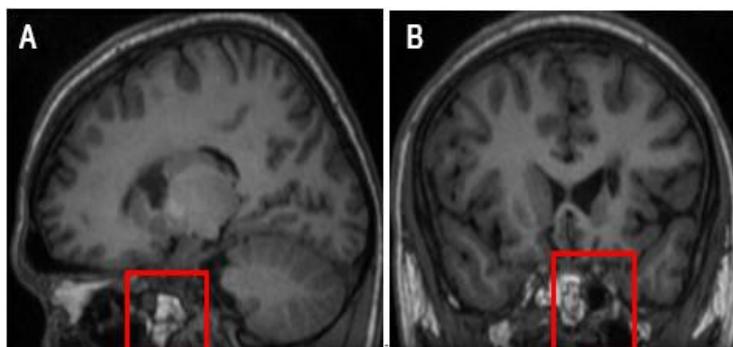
Postoperative follow-up brain MRI: sagittal T1-weighted images. The autologous graft is marked within the red square
